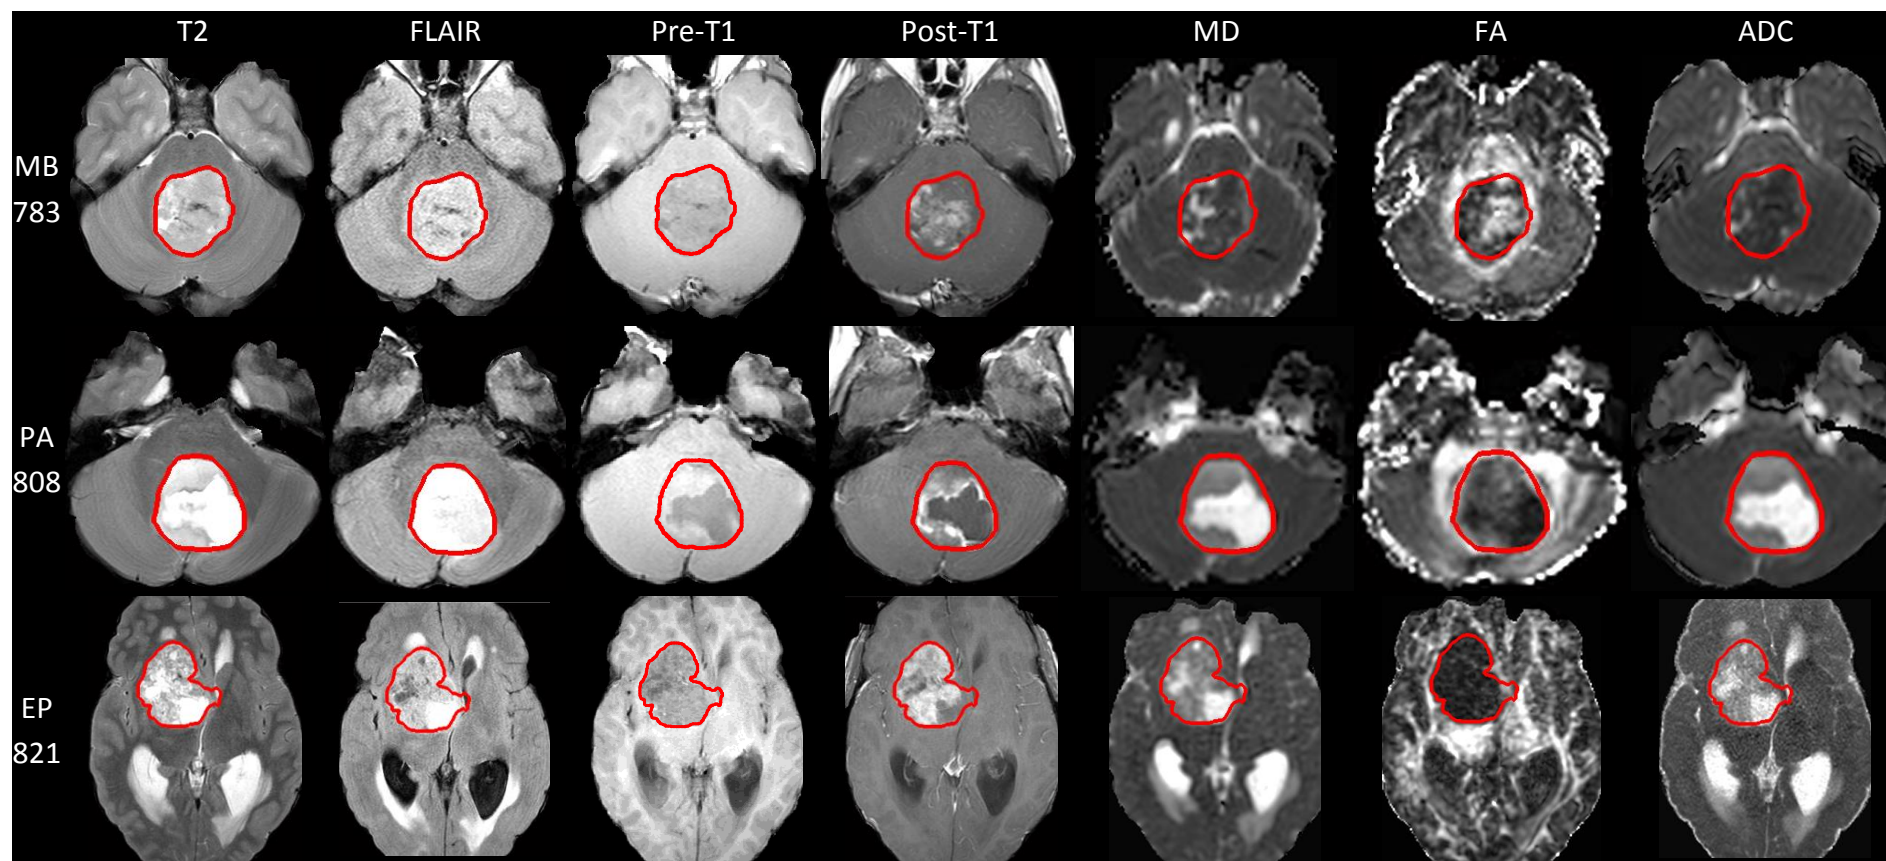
Tumour boundaries of the three tumour types. Tumour boundaries of medulloblastoma, pilocytic astrocytoma and ependymoma based on T2, FLAIR, pre-contrast T1, post-contrast T1, MD, FA, and ADC. A typical case of each tumour type is shown: cases MB783, PA808 and EP821.
